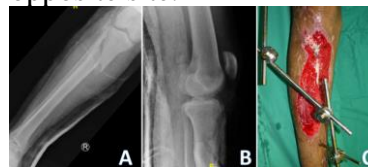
Injury (A) anteroposterior and (B) lateral radiographs demonstrating comminuted fracture of proximal third right tibia. Exposed tibia bone and patella tendon (C)
